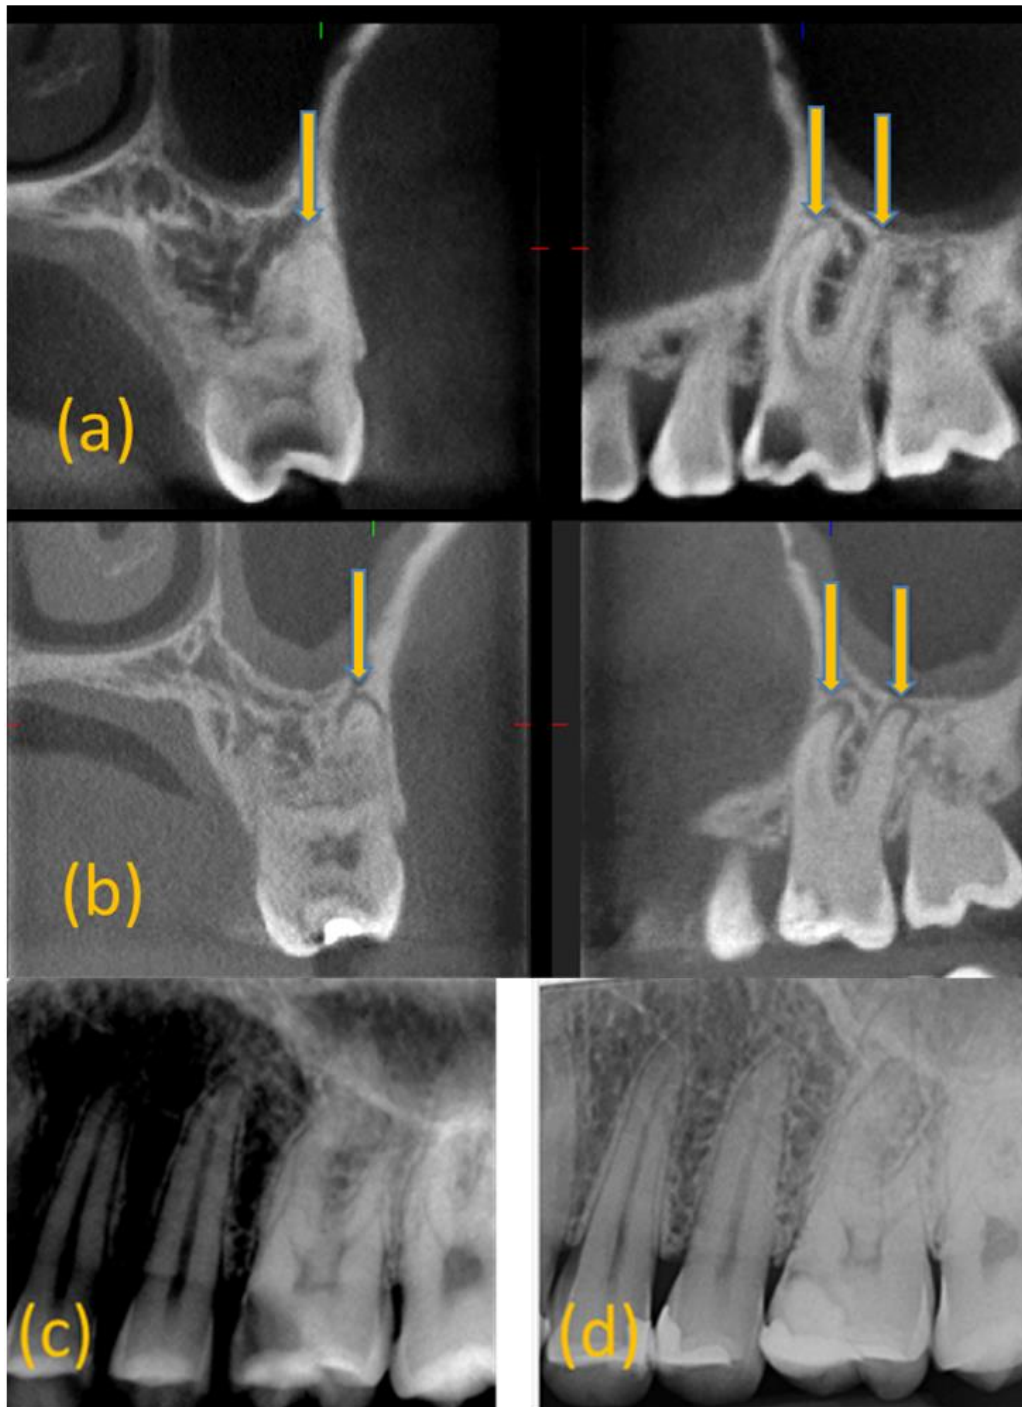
Example of new lesion (a) CBCT at T0 revealing healthy periapical tissues surrounding the roots of the upper left 6. (b) CBCT at T12 revealing lesions around the roots of the same tooth.(c) PA radiograph at T0 revealing healthy periapical tissues around the tooth.(d) PA radiograph at T12 revealing slight widening of the PDL around the same tooth.
